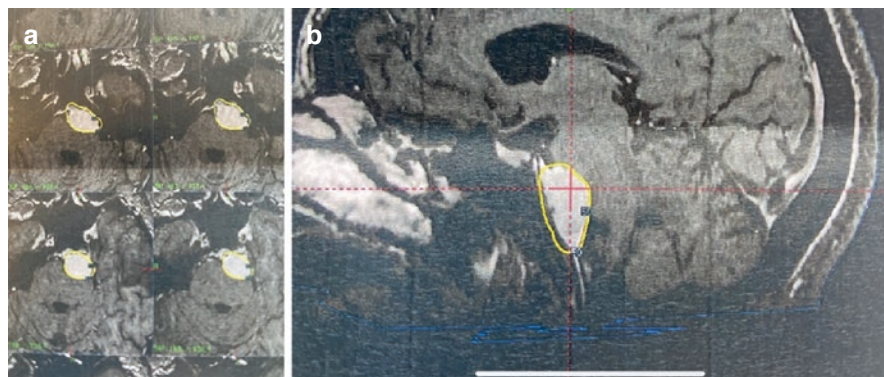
This is a 67-year-old man incidentally discovered to have a moderate sized petroclival meningioma. He was treated uneventfully with Gamma Knife (a: axial MRI postcontrast images from the day of Gamma Knife treatment; b: sagittal MRI postcontrast image from the day of Gamma Knife treatment)
